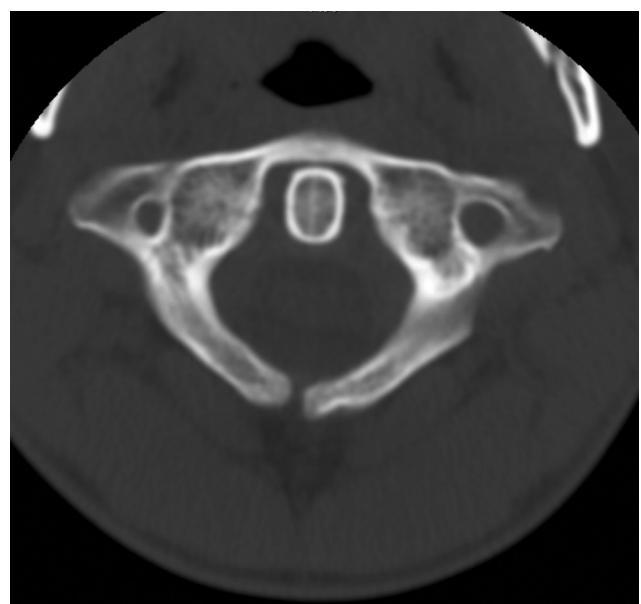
Axial view of CT cervical spine at the level of C1: nonunion of the posterior arch. CT, computed tomography.
